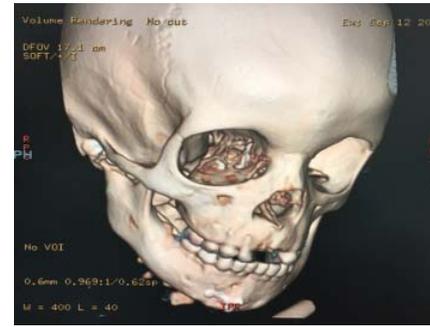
Maxillofacial 3D CT scan after one month
